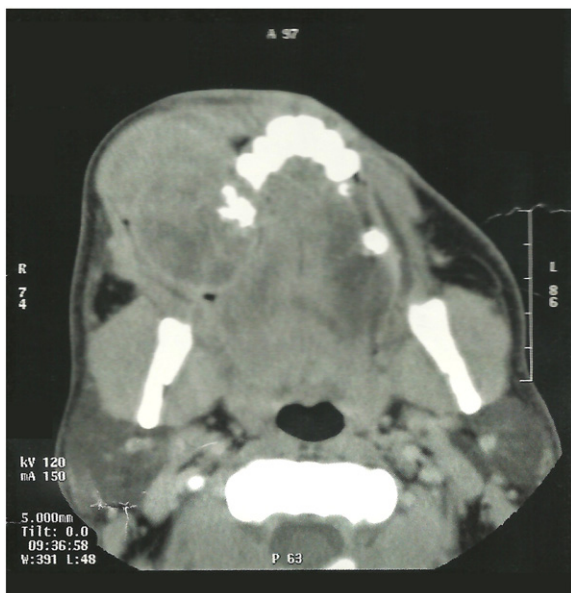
CT demonstrating a tumor in the maxilla adjacent to the skin of the face.
